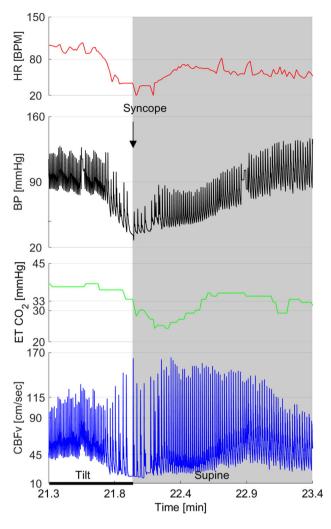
Transcranial Doppler and autonomic findings on tilt test in syncope—a detailed recording when syncope occurs, showing the physiological responses of the subjects to head-up tilt in terms of BP, HR, ET CO_2 , CBFv in syncope Image courtesy of Dr. Peter Novak
